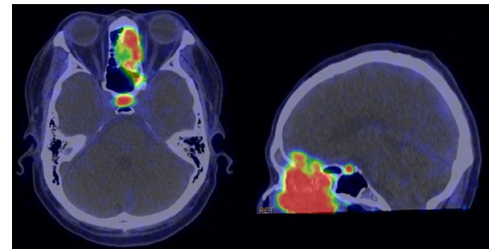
PET-CT Ga-68 DOTATOC
